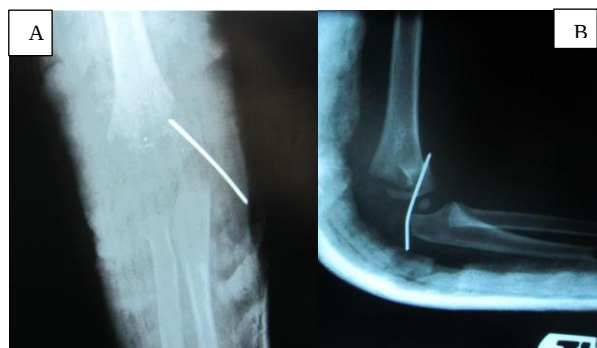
A) Anteroposterior (AP) elbow radiograph obtained immediately after closed reduction and percutaneous fixation with one lateral Kirschner wire (K-wire), showing restored coronal alignment and appropriate pin position and spread; B) Lateral elbow radiograph obtained immediately after pinning, confirming maintenance of reduction with congruent ulnohumeral alignment and satisfactory pin trajectory
